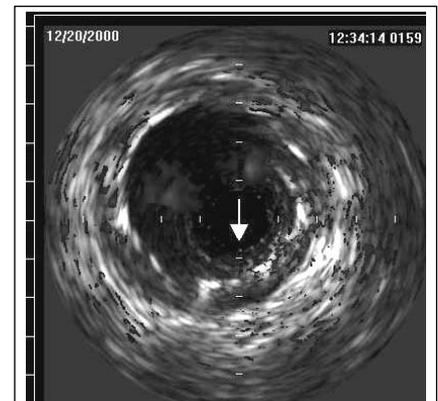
C, D. Identification of the unexpanded state of the stent at IVUS, angiographic and ultrasonic control after the additional angioplasty in a stent
